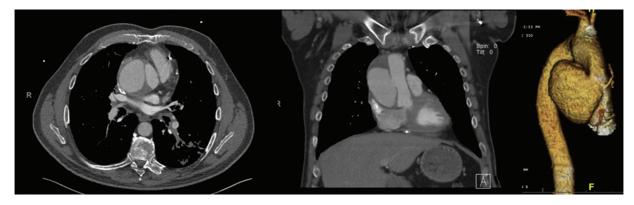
Preoperative computed tomography with three-dimensional reconstruction demonstrating large pseudoaneurysm at mid-ascending aorta.
